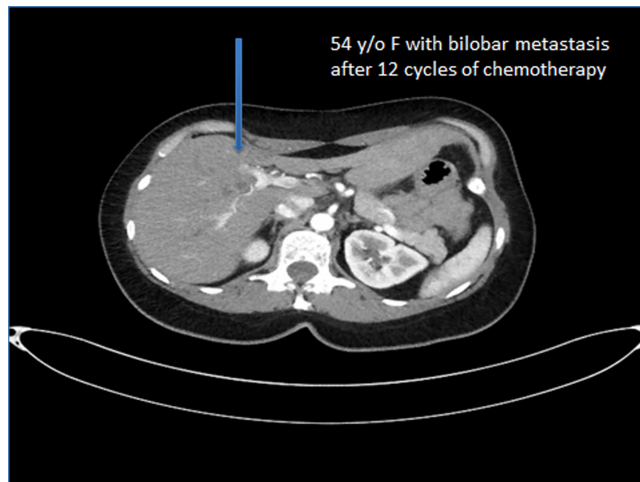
CT scan demonstrating a colorectal metastasis situated at the bifurcation of the right and anterior and posterior sectoral inflow vessels. This patient had bilobar metastases and underwent left hepatectomy at the time of IRE.
